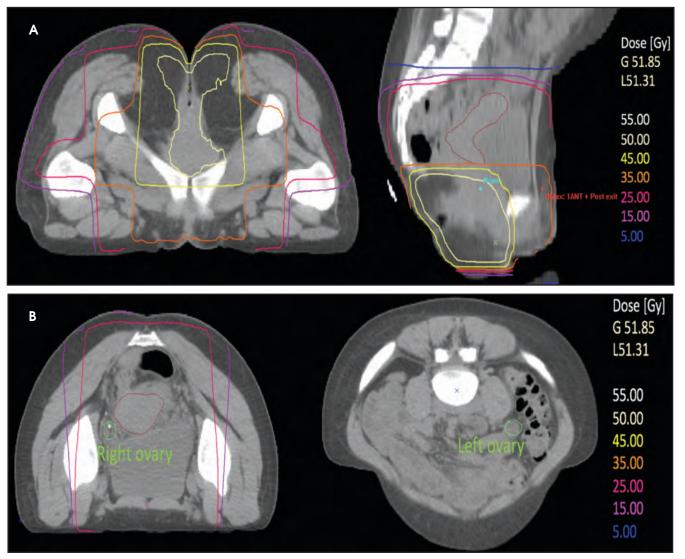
Transverse and sagittal plane images of planning computed tomography (CT) demonstrating radiation dose delivered to pelvic structures (A). Images of a radiation therapy planning CT with both ovaries outlined; note the left ovary has been transposed into the abdomen prior to commencing radiation therapy (B).
